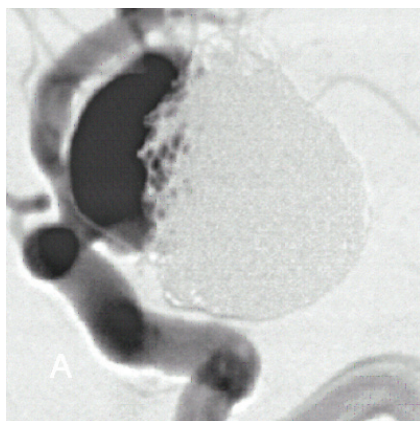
A 39-year-old male experienced oculomotor nerve paresis, and a large unruptured OphtA aneurysm was treated with coil embolization. Residual filling in the aneurysm sac was detected in follow-up angiography (A). CT revealed bleeding due to aneurysm rupture (B) 51 months after the initial treatment and 3 months after the last angiographic follow-up. (case 147, Appendix, cases of recurrent bleeding)
